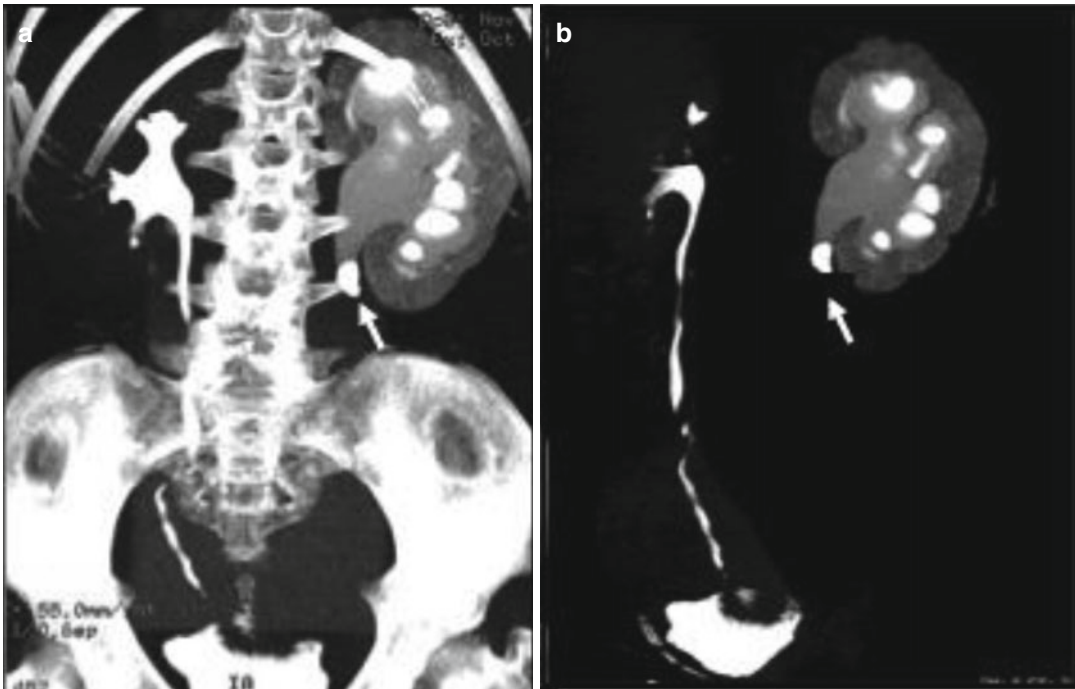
(a, b) 3D MIP CT reconstructions show a large stone obstructing the left ureteropelvic junction with proximal hydronephrosis and an absence of urinary tree contrast opacification distally to the stone (arrows)
